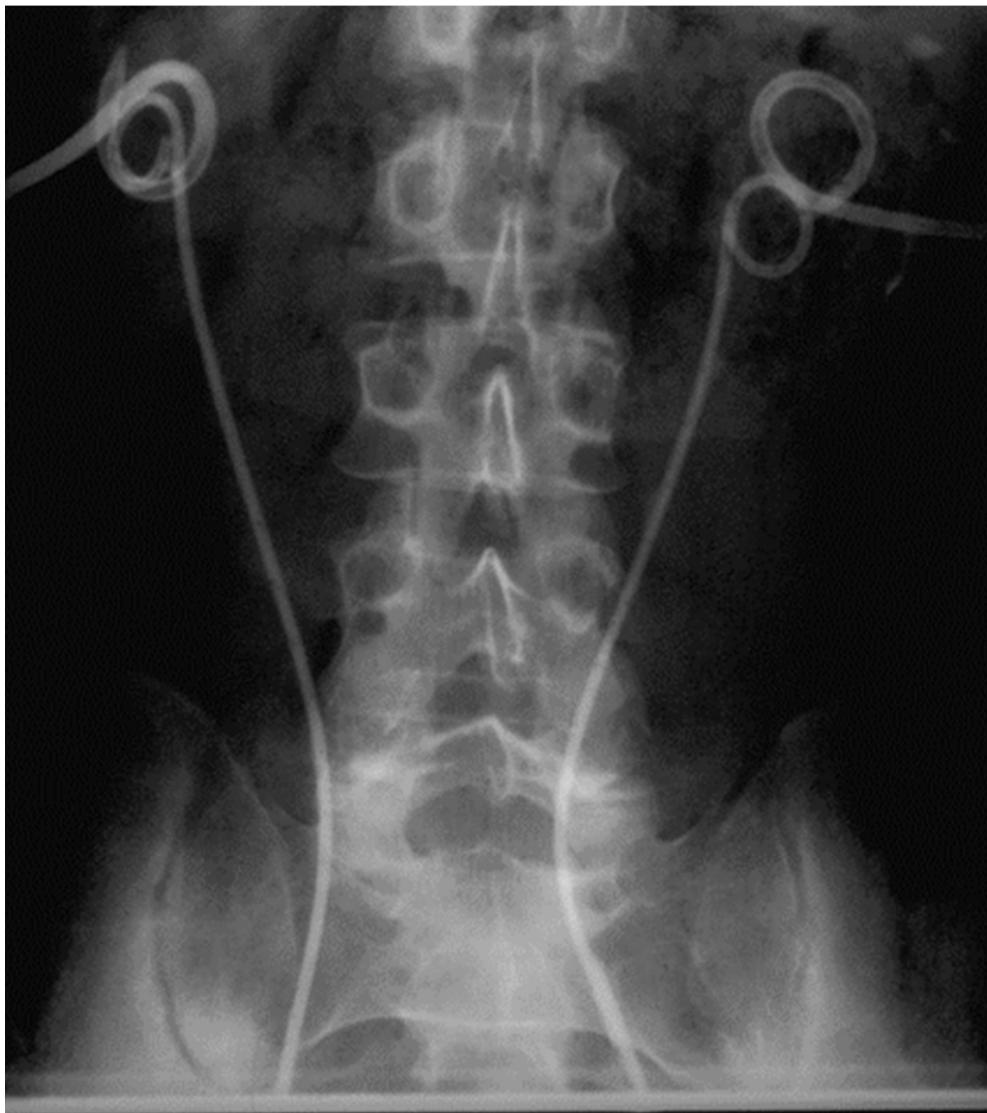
A plain film radiograph demonstrating the proximal position of the patient's ureteral stents and nephrostomy tubes.
